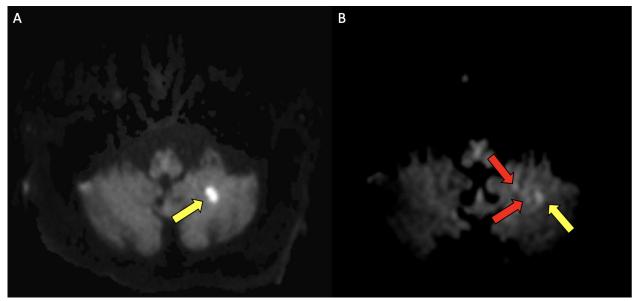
MRI of the brain at presentation (A) demonstrates area of restricted diffusion in the left cerebellar hemisphere (yellow arrow). MRI of the brain one month later (B) demonstrates stippled new areas of restricted diffusion (red arrows) adjacent to the original lesion (yellow arrow).
